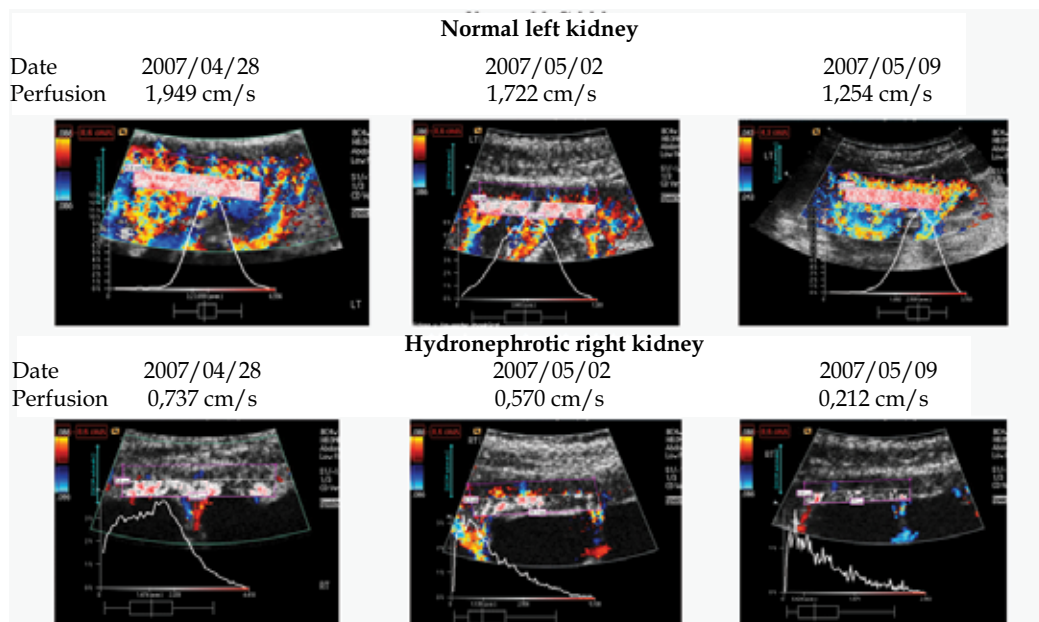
Differing response of both kidneys towards an bacterial infection in a patient with a right sided hydronephrosis. Perfusion intensity in the proximal cortex. MAG3 scintigraphy right kidney: 30% of both kidneys' function. Renal perfusion in a child with a normal kidney on the left and a hydronephrotic kidney on the other side. Inflammation due to bacterial infection causes an initial perfusion increase (2007/04/28). With recovery perfusion drops in both kidneys (from 2007/05/02 to 2007/05/09). The decline is more pronounced in the hydronephrotic kidney. Perfusion intensity distribution curves differ markedly between both kidneys pointing to the damage of the microvasculature in the hydronephrotic kidney and a compensatory hyperperfusion through dilated microvasculature on the left side
